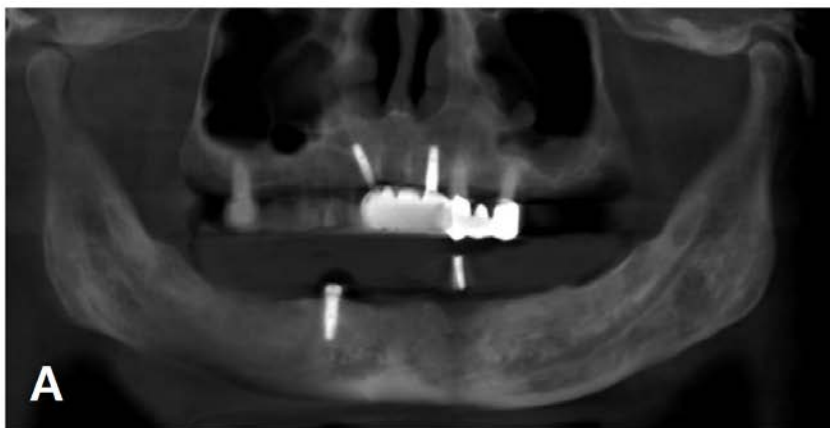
CBCT image taken 5 months after ARP. (A) Panoramic view, (B) Paraxial view: thick cortical bone on the lingual side was detected.
